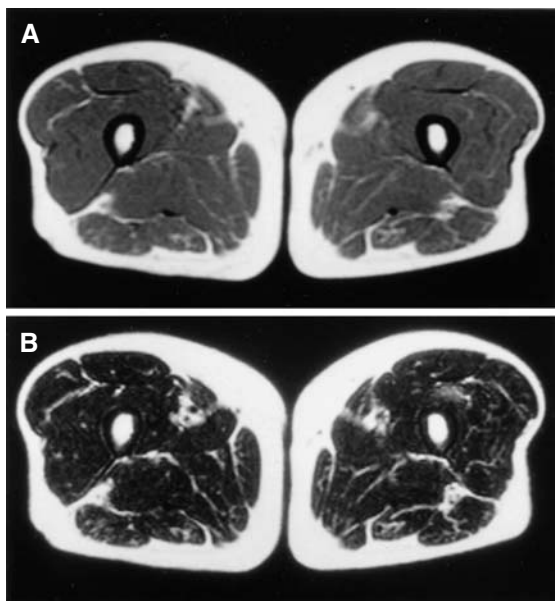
Magnetic resonance imaging of thigh muscles in patient 1. A normal T1-weighted image (A) contrasts with high signal intensities in a T2-weighted image (B) of the left vastus intermedius muscles
